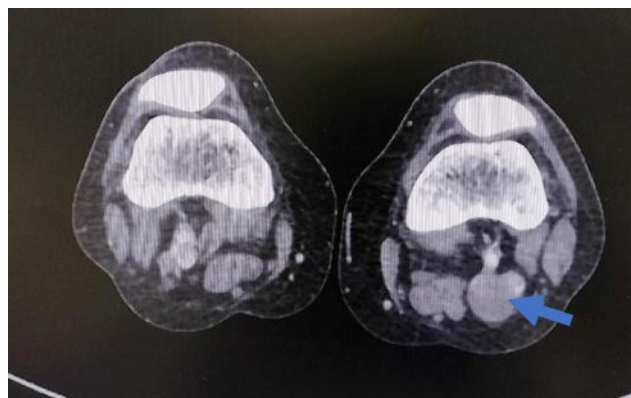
CT scan (axial view) - presence of popliteal vein aneurysm with a maximum calibre of 22 mm (arrow).
